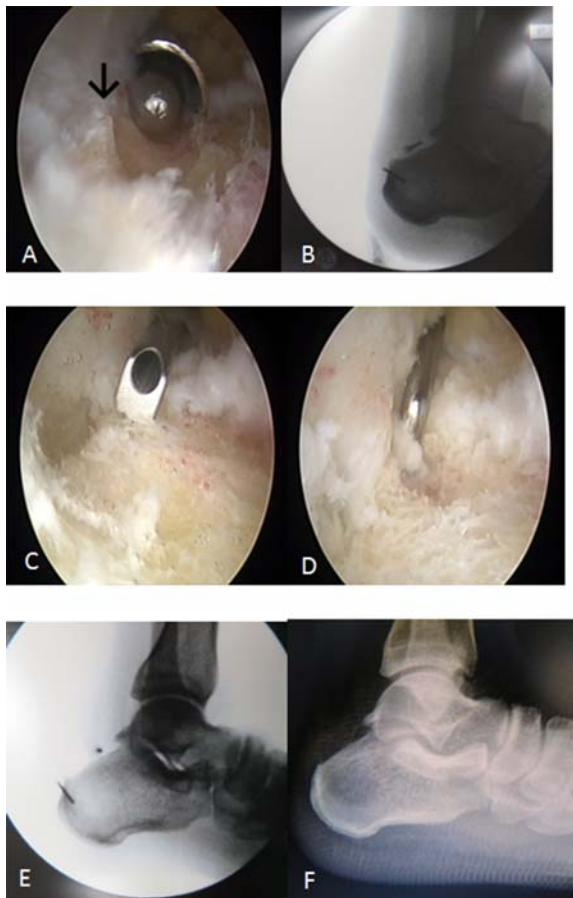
Endoscopic images and fluoroscope: (A), posterosuperior bony bump was resected by mastoid burr and bony bump that difficult to resected by mastoid burr (black arrow); (B), fluoroscope was used to check bony bump that closed to Achilles tendon was not resected; (C), ultrasonic surgical instrument was used; (D), bony bump that closed to Achilles tendon was resected; (E), fluoroscope was used to check bony bump that closed to Achilles tendon was resected; (F), post-operative radiograph.
